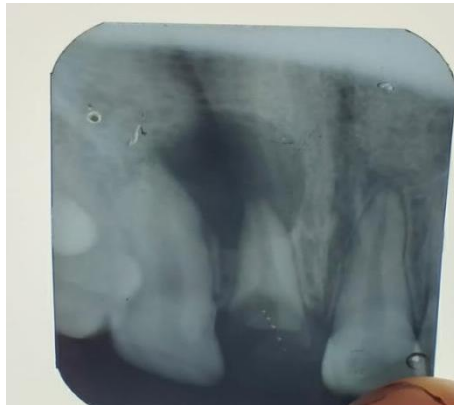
Pre-operative radiograph (IOPA)
